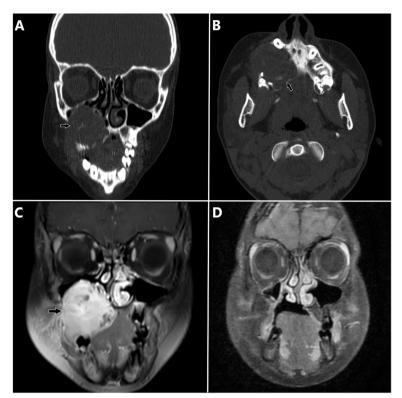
Case 5. a Coronal view of CT, destruction of lateral maxillary sinus wall. b Axial view of CT, destruction of the hard palate. c Preoperative coronal view of T1 enhanced MRI. d Postoperative coronal view of T1 enhanced MRI
